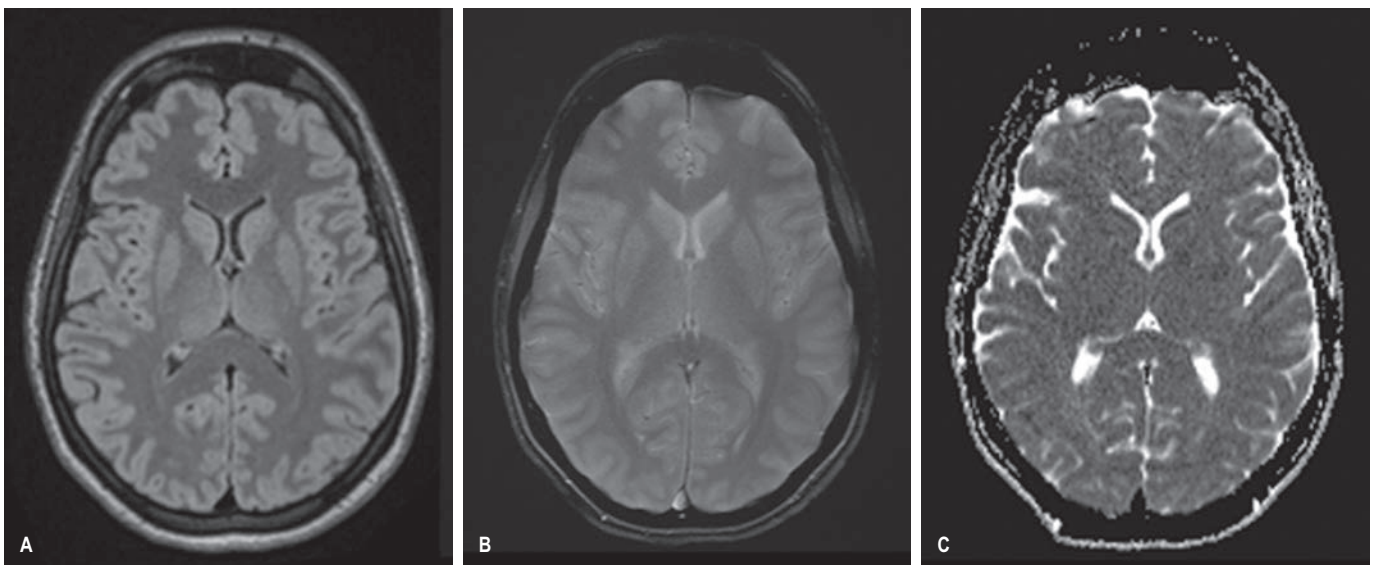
Other Magnetic Resonance Imaging Techniques. *Left:* (A) FLAIR (fluid-attenuated inversion recovery) sequence; *centre:* (B) T2 gradient image; *right:* (C) diffusion ADC image.
